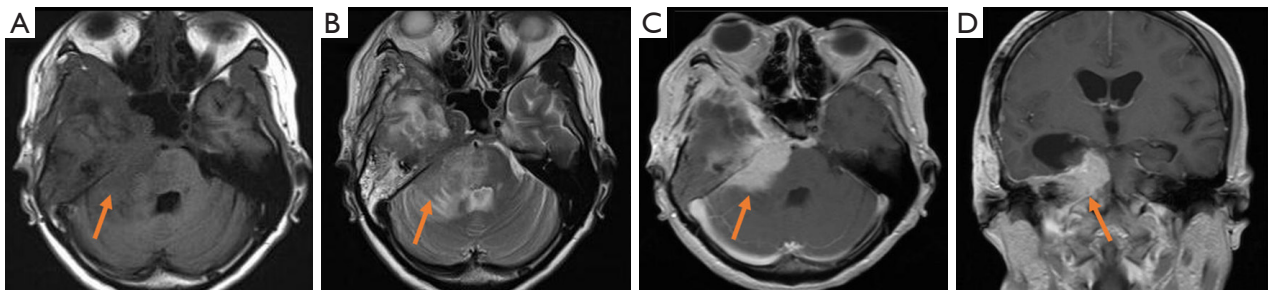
MRI findings revealed that the lesion had partially decreased in size, the compression on the cerebellum and brainstem had increased after surgery and radiotherapy. (A) MRI showed an isointense lesion on T1-weighted imaging (arrow). (B) MRI showed an isointense lesion on T2-weighted imaging (arrow). (C) MRI showed a hyperintense mass on axial enhanced T1-weighted imaging (arrow). (D) MRI showed a hyperintense mass on coronal enhanced T1-weighted imaging (arrow). MRI, magnetic resonance imaging.
